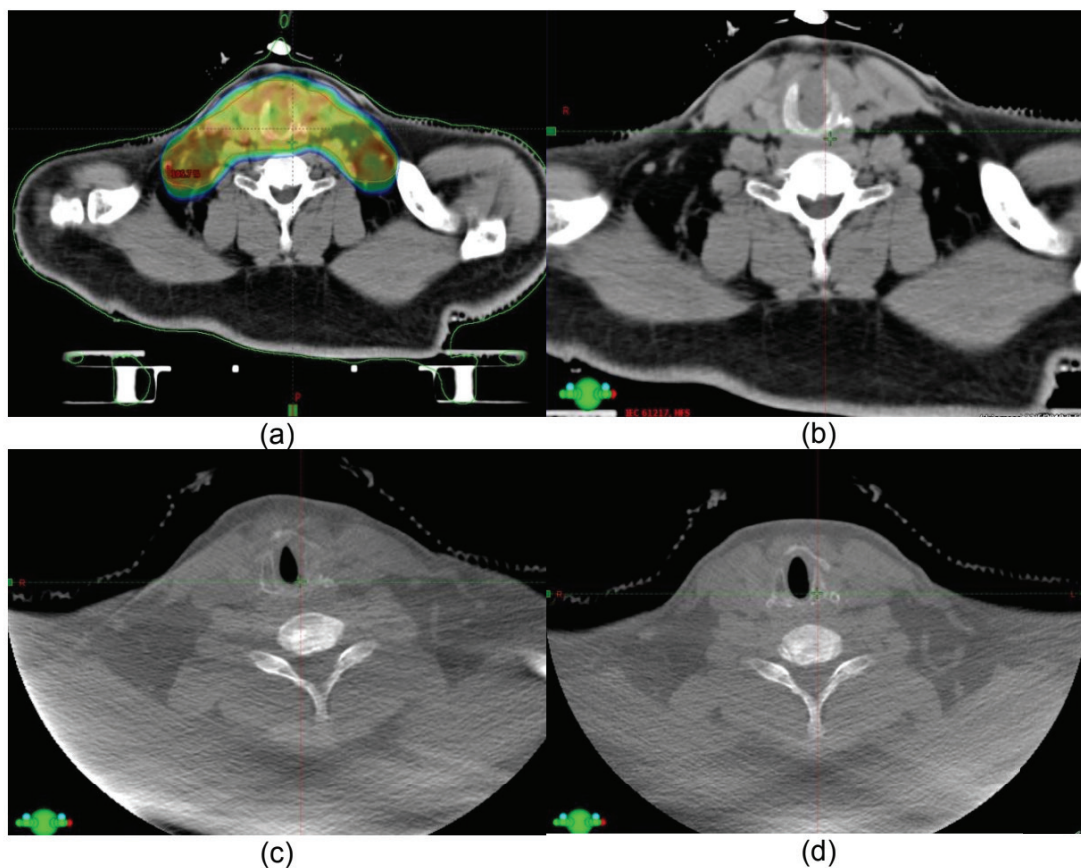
Pre-, middle and post-treatment progression of the lesion through computed tomography scan including an external beam planning for radiotherapy (a) External Beam Planning contour, (b) Pre-treatment, (c) Middle of treatment, (d) Post-treatment
